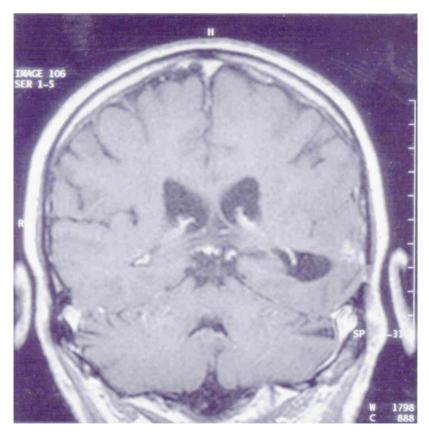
Coronal T1-weighted MR image after administration of iv gadolinium showing the radiological lesions disappearing under treatment.
